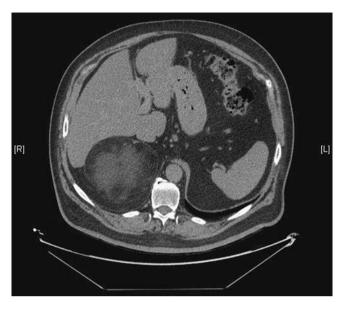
Non-contrast axial CT image of a myelolipoma of the right adrenal gland
